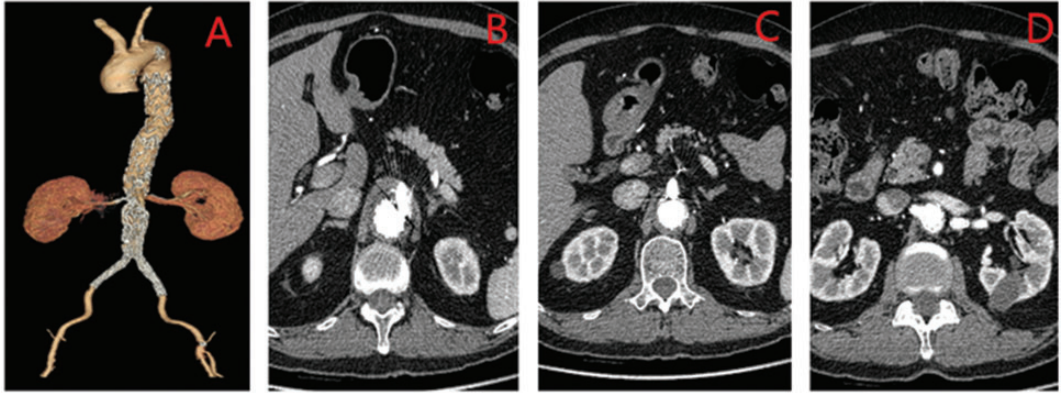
Postoperative computed tomographic angiography images at 3 months after the final surgical stage in a 66-year-old male with a thoracoabdominal aortic aneurysm (Crawford type III): (A) three-dimensional image of the aorta and iliac artery; (B–D) no endoleaks were observed at the celiac trunk, superior mesenteric artery, and renal artery levels, respectively. The colour version of this figure is available at: <http://imr.sagepub.com>.
